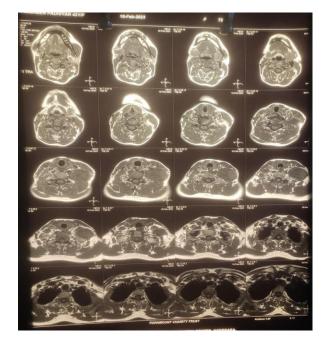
MRI Scan with vertical slices.
